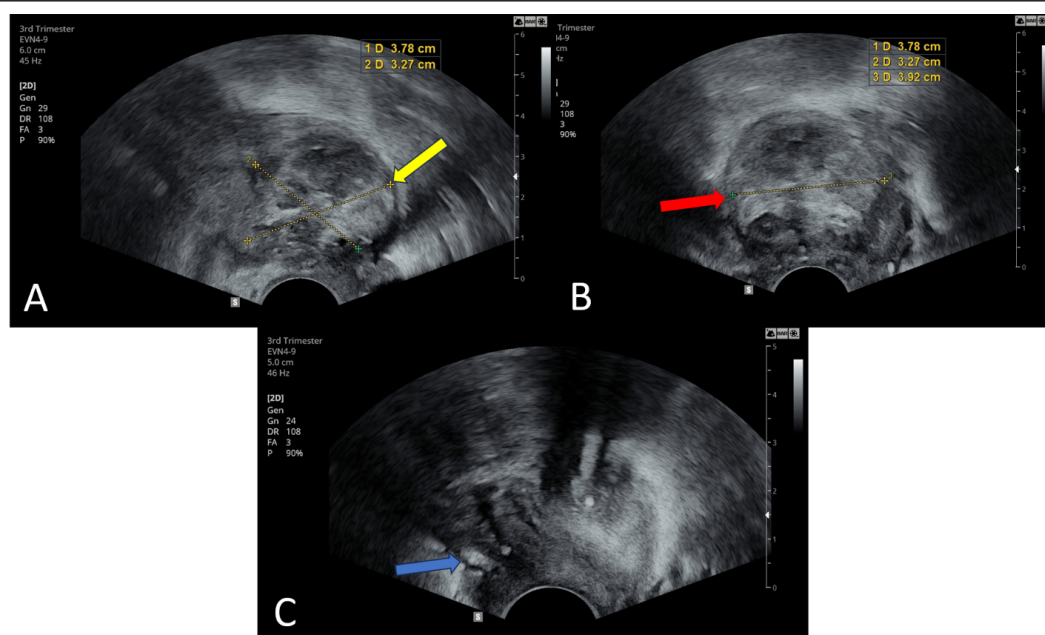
Post-evacuation transvaginal ultrasound assessment demonstrating (A) measurement of intracervical hematoma with anteroposterior and longitudinal diameters (yellow arrow showing measurement calipers), (B) transverse diameter measurement of the organized hematoma (red arrow), and (C) color Doppler evaluation showing echogenic appearance of residual cervical circulation (blue arrow). The presence of an organized hematoma is expected following dilatation and evacuation, with serial monitoring ensuring gradual resolution and successful hemostasis.
